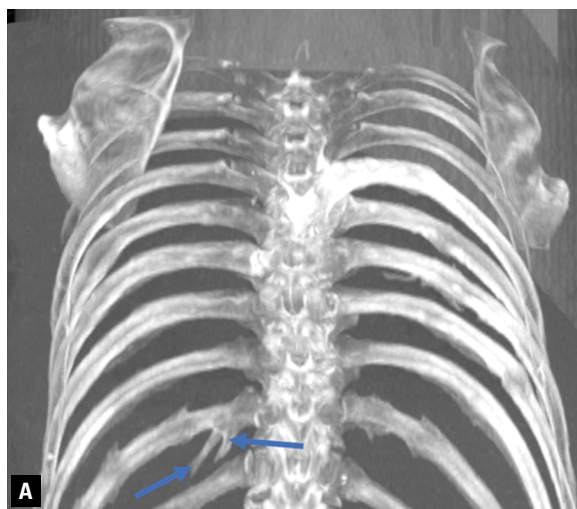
Spurs on the left 11th rib on the coronal computed tomography image (A) and three-dimensional image (B).
